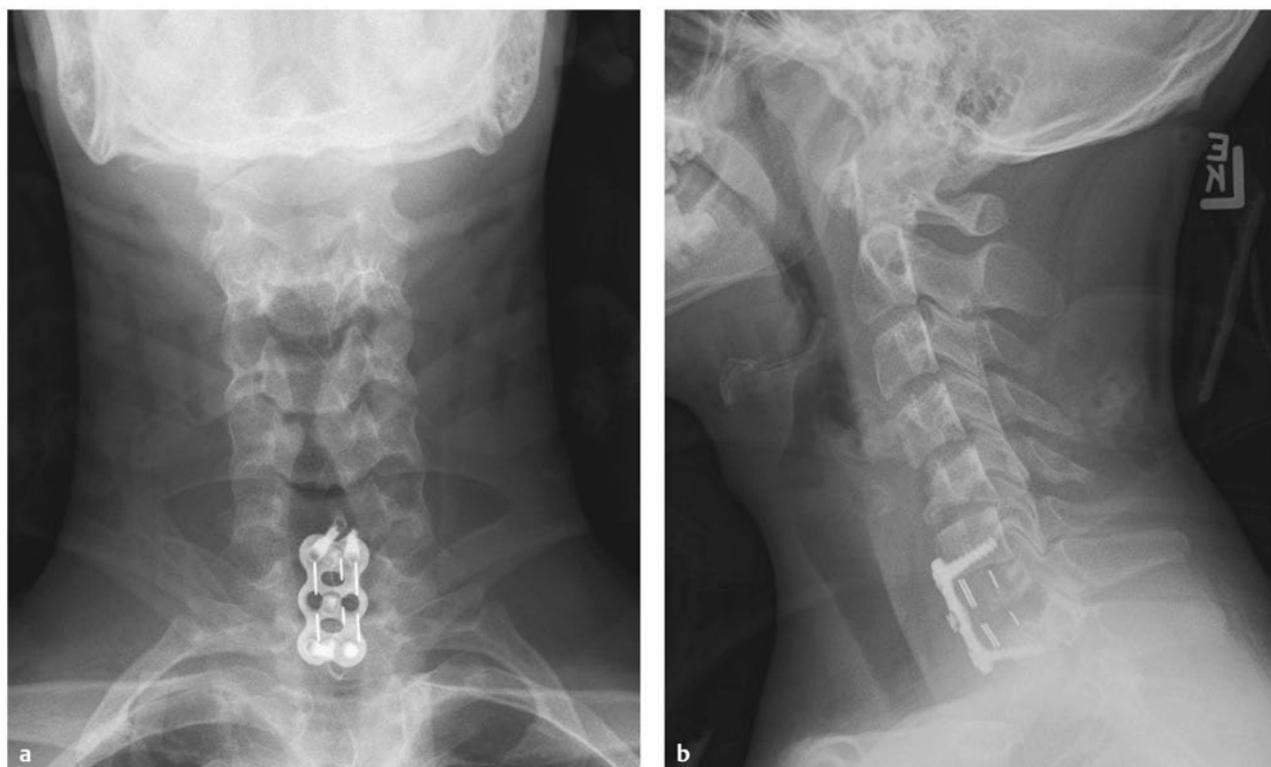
C7 burst fracture. Postoperative (a) anteroposterior and (b) lateral radiographs of the patient in ▶ Fig. 61.12 demonstrating decompression via an anterior C7 corpectomy with placement of a synthetic interbody graft and anterior plating from C6 to C8.
